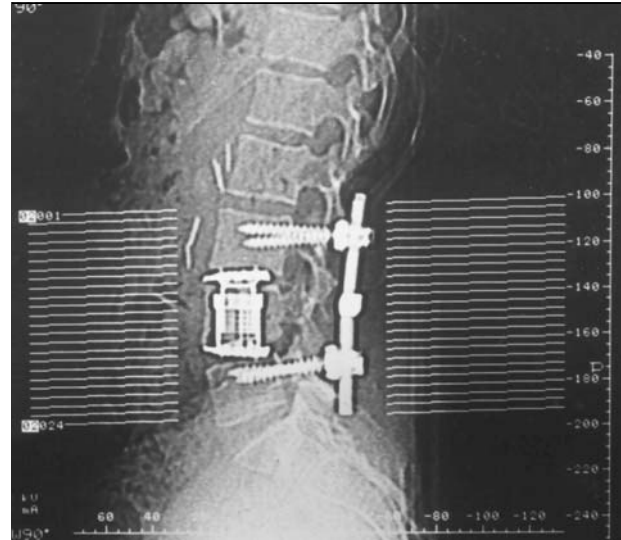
Postoperative CT after lumbar vertebral body reinforcement using titanium mesh cage and posterior instrumentation.
